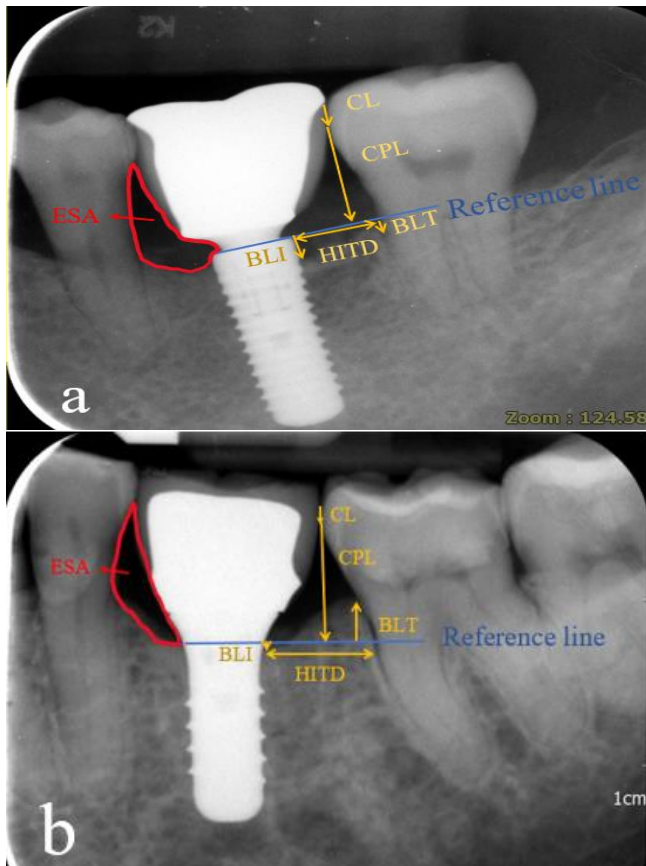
Radiographic measurement at proximal space between implant supported single crown and adjacent natural tooth in radiographic images.
